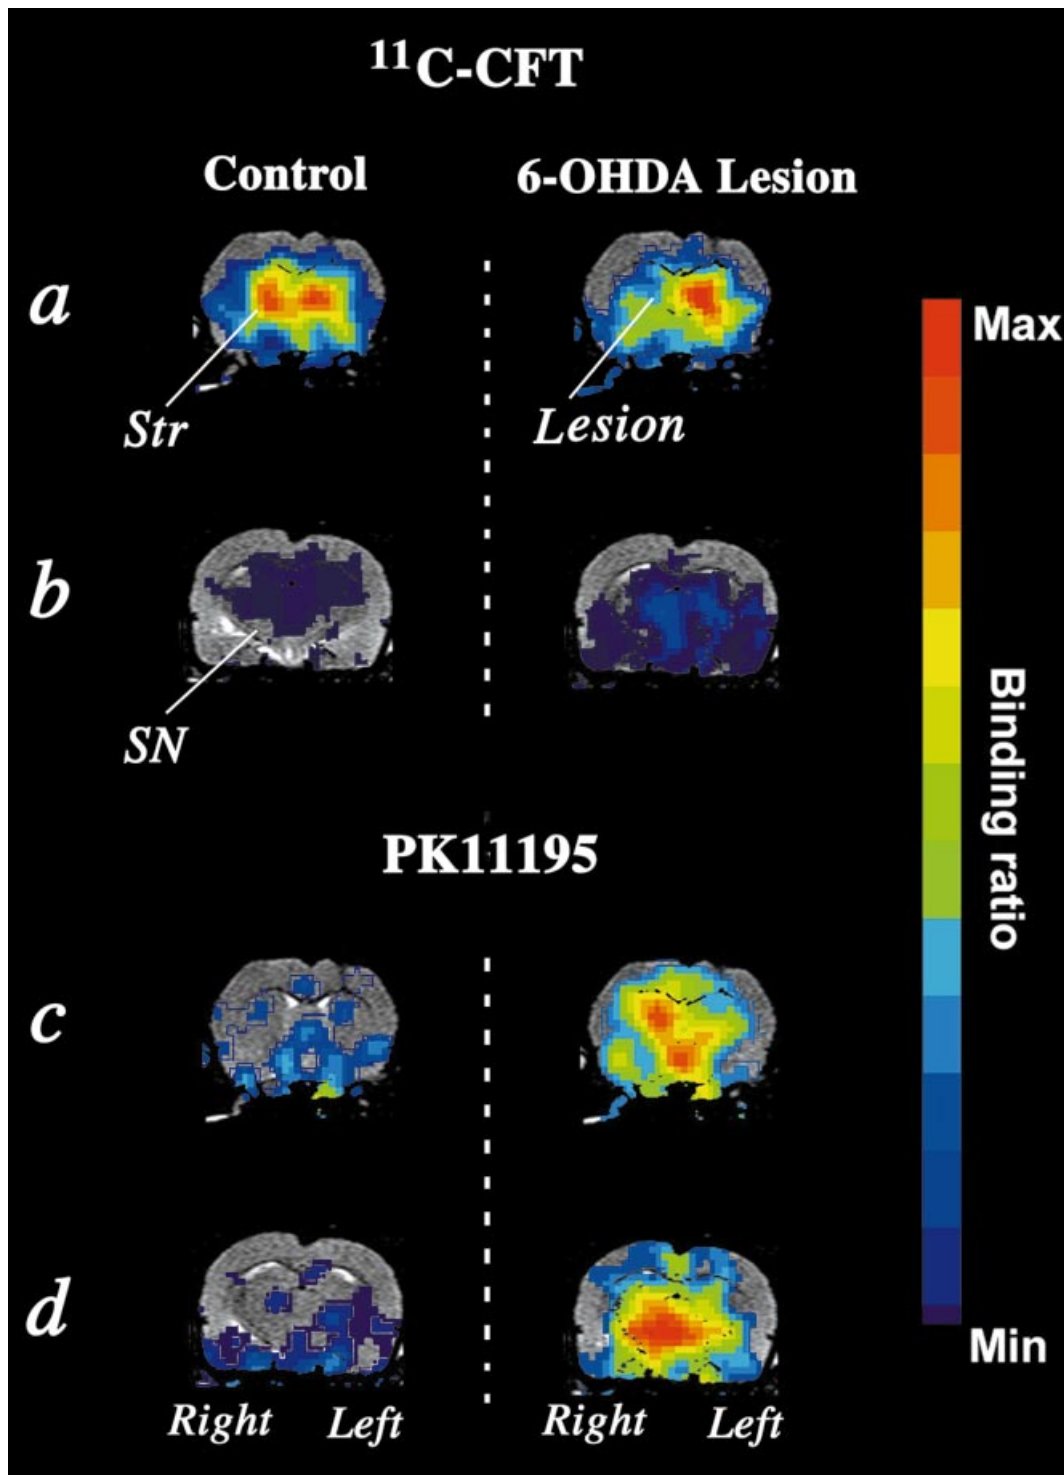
Neuroinflammation of the nigrostriatal pathway during progressive retrograde dopamine degeneration induced from striatal location. Colour-coded images, overlaid on magnetic resonance images for anatomical precision, showing a significant decrease in binding parameters of $^{11}\text{C-CFT}$ (dopamine uptake sites located on presynaptic terminals) after unilateral intrastratial infusion of the toxin 6-hydroxydopamine (6-OHDA) (on the right side of the brain) (a). Because of size and reduced number of binding sites, it is not possible to accurately detect and estimate binding potential in the substantia nigra (b). The process of selective dopamine axonal degeneration was paralleled by a significantly increased striatal binding of the peripheral benzodiazepine receptor $^{11}\text{C-PK11195}$, which is expressed primarily on reactive microglia during central nervous system inflammation (c). A dramatic increase in $^{11}\text{C-PK11195}$ binding was also seen in the ventral mesencephalon at the level of the substantia nigra (SN) of the striatally (Str) infused side (d). (a) to (d) are all at 21 days after 6-OHDA lesion.
